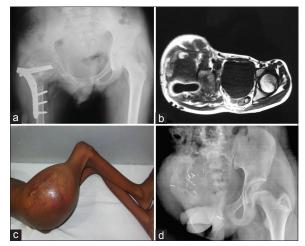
(a) Radiograph showing osteosarcoma of proximal femur with pathological fracture with plate *in situ* (b) T1 axial magnetic resonance image showing osteosarcoma of proximal femur with soft tissue component. (c) Clinical picture showing large swelling in the proximal femur with surgical scar. (d) Patient underwent palliative hindquarter amputation in view of extensive metastasis. Radiograph showing post hindquarter amputation status
